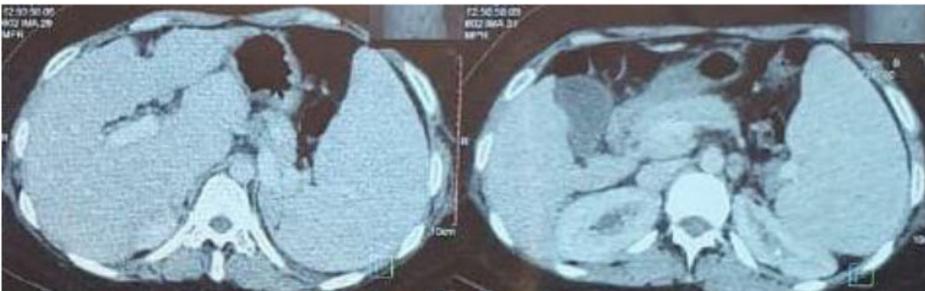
Abdominal computed tomography (CT)-scan of the patient suggests early cirrhosis and splenomegaly.
